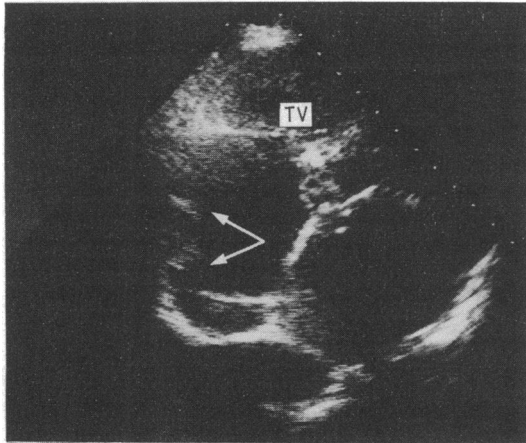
Cross sectional echocardiogram in the short axis parasternal view showing sessile clot (arrows) on the lateral wall of the right atrium.
